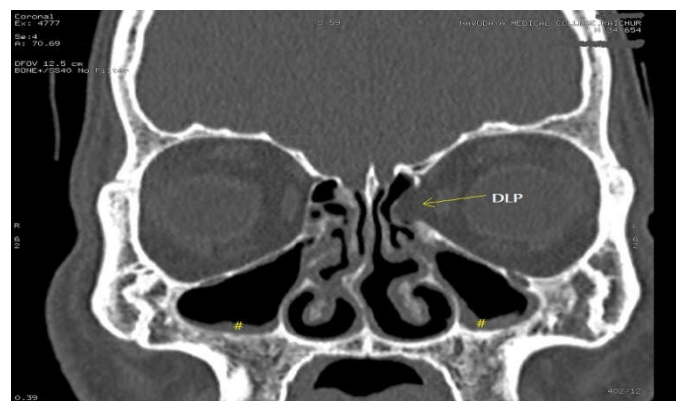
Coronal CT image show focal dehiscence of the left lamina papyracea (yellow arrow) with focal herniation of orbital fat into ethmoid sinus filling the ethmoid bulla. DLP: dehiscence of lamina papyracea, #: mucosal thickening.
